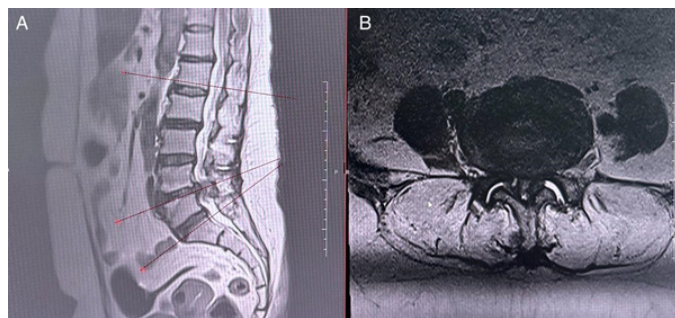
2: Lumbar MRI at L4-5 level (the level with disc herniation), T2 sequence, sagittal (A) and axial (B) slices.
